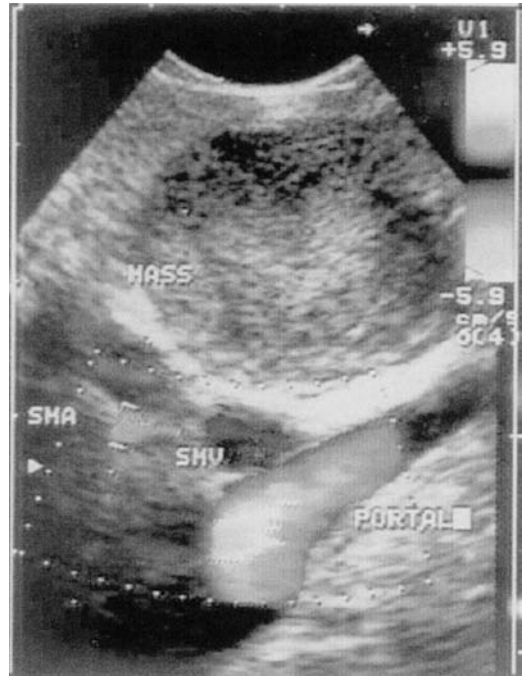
Endoscopic ultrasound (EUS) image with linear array echoendoscope demonstrating a mass in the head of the pancreas with no vascular invasion of the superior mesenteric artery (SMA), superior mesenteric vein (SMV), or portal vein (PORTAL). (Reproduced with permission from Yeo CJ, et al. Pancreatic cancer. *Curr Probl Surg.* 1999;Feb;36(2):59–152.)
